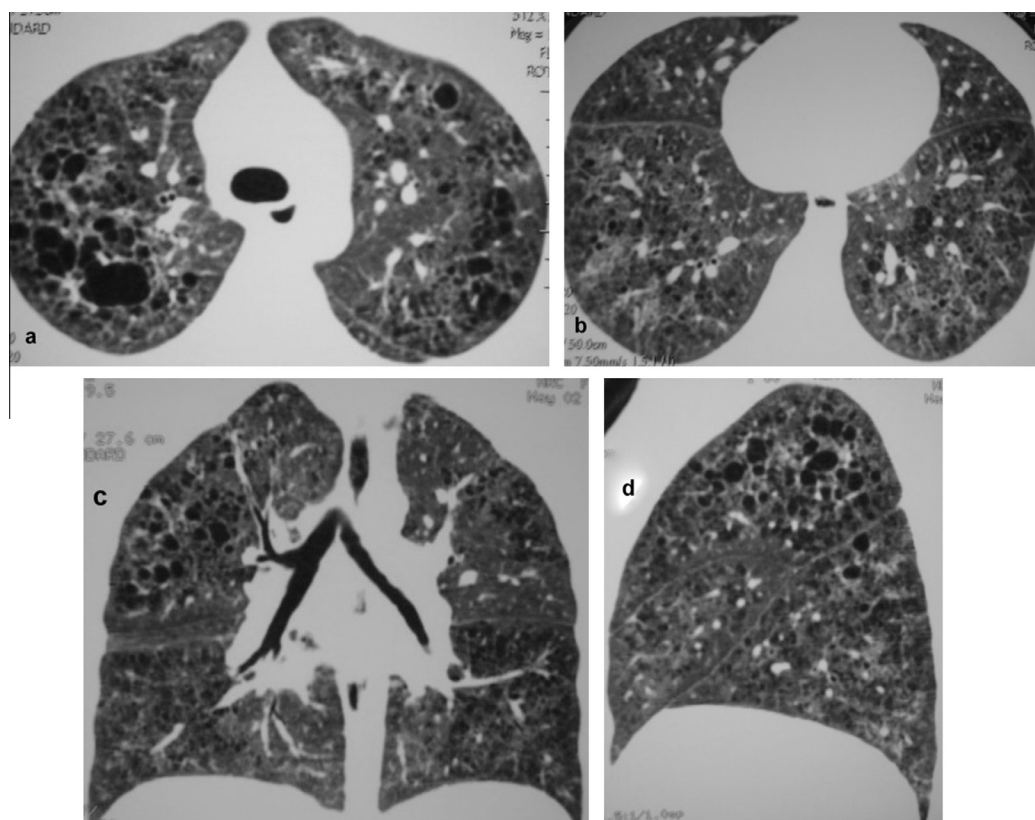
(a–d): 35-year-old female patient with LAM presenting with dyspnea and dry cough. HRCT in axial (a, b), coronal (c) and sagittal (d) reconstructed images showing bilateral numerous air-filled cysts, predominantly upper lobar (a, c, d) together with thickened interlobular septa and fissures. Most cysts are less than 1.5 cm in diameter; however, a right upper lobar cyst (a) is seen measuring about 2 cm.
